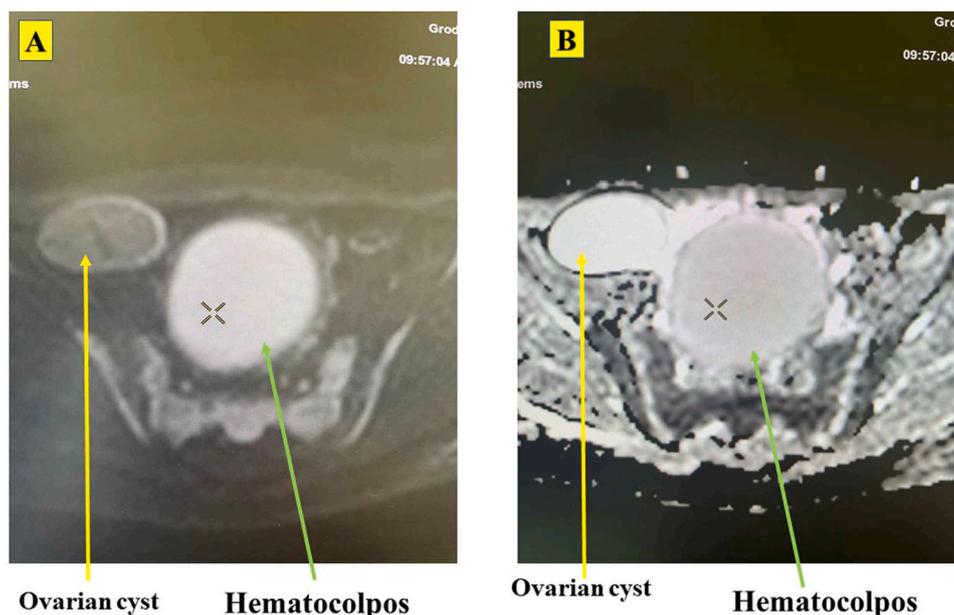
(A) Axial DWI (Diffusion-weighted imaging) image; (B) Axial ADC (Apparent Diffusion Coefficient) image.
